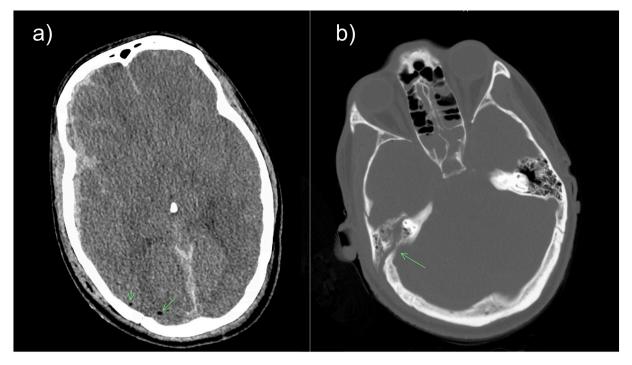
CT of the head without contrast revealing (a) pneumocephalus and (b) basilar skull fracture involving mastoid air cells in bone view.
